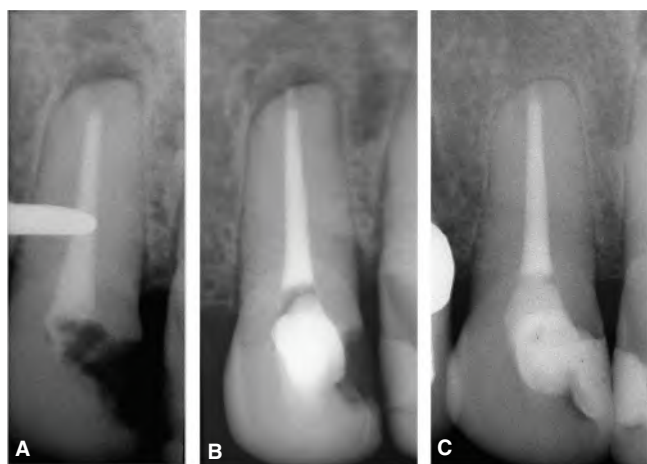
Nonsurgical endodontic retreatment in a maxillary lateral incisor of a 28-year-old female. The tooth was symptomatic on percussion. A. Preoperative radiograph showing periradicular radiolucency associated with the affected tooth. The coronal obturation is missing and the pulp chamber is open to the oral cavity. B. Immediate postoperative radiograph. C. 17-year follow-up radiograph showing resolution of the periradicular radiolucency. The tooth was asymptomatic throughout the entire follow-up period.
